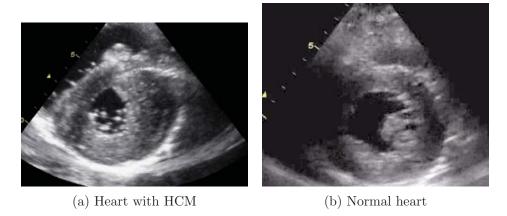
Parasternal short axis echocardiogram midpapillary level display with HCM and a normal heart. Both hearts are shown while the left ventricle is contracted. Note the larger size of the left ventricular wall and smaller left ventricle in the HCM image [10].
